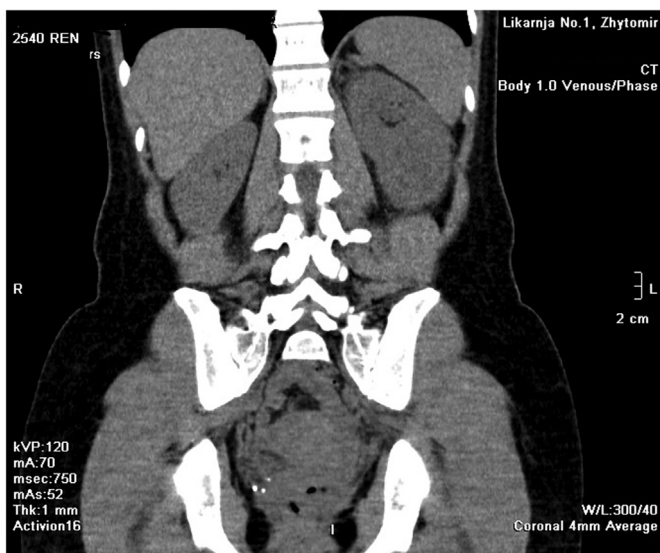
Coronal images of the CT of the abdomen show no obstructing source.
